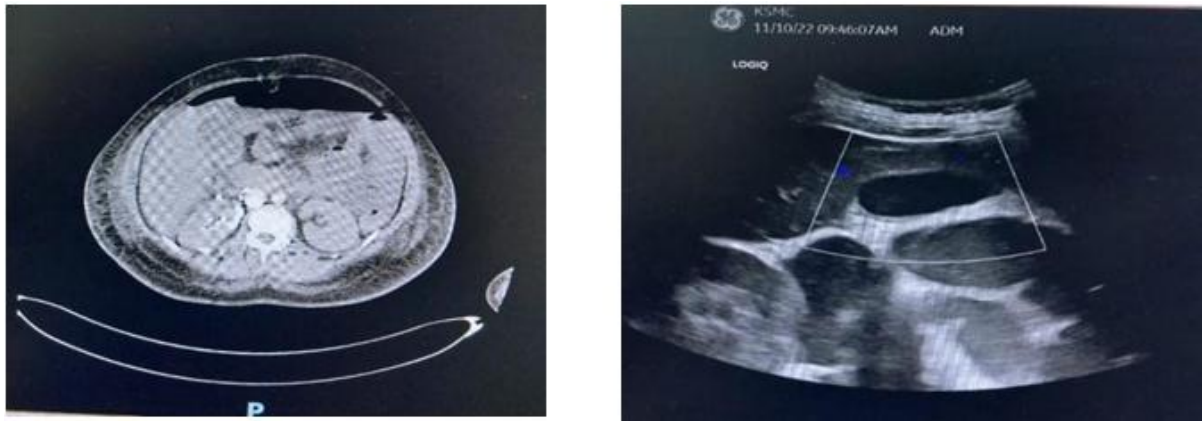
Upper abdominal ultrasound reveals: multiple dilated fluid filled bowel loops, and moderate free fluid in peritoneal cavity.
